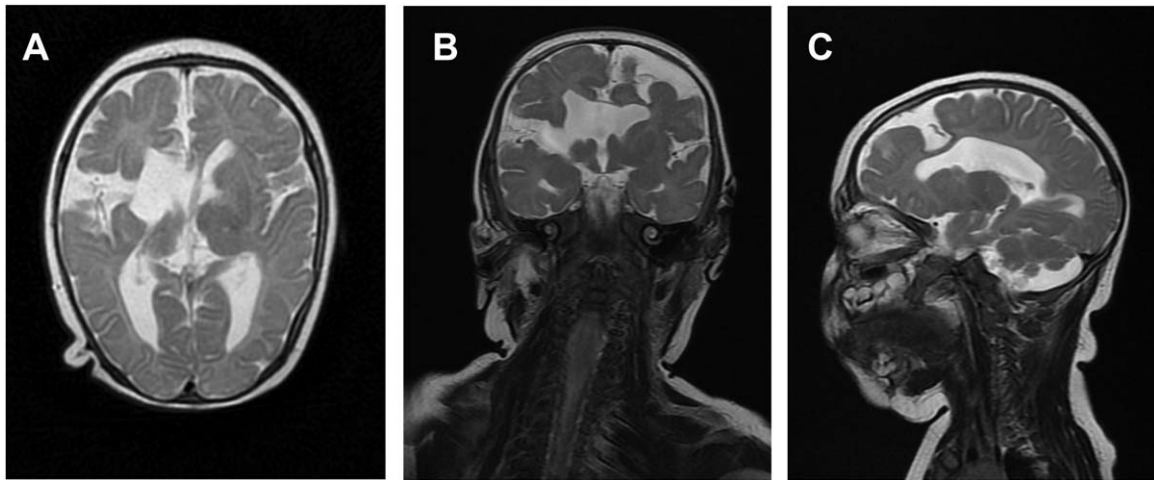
MR study of the proband brain, T2-weighted axial (A), coronal (B), and sagittal (C) images. Schizencephaly with open-lip cleft between the Sylvian fissure and lateral ventricle is seen on the right (A,B), while on the left, there is schizencephaly with closed-lip cleft in the frontal lobe (B,C). There is also a visible absence of septum pellucidum (A) as well as enlargement of the ventricles (especially right lateral ventricle) and subarachnoid spaces.
